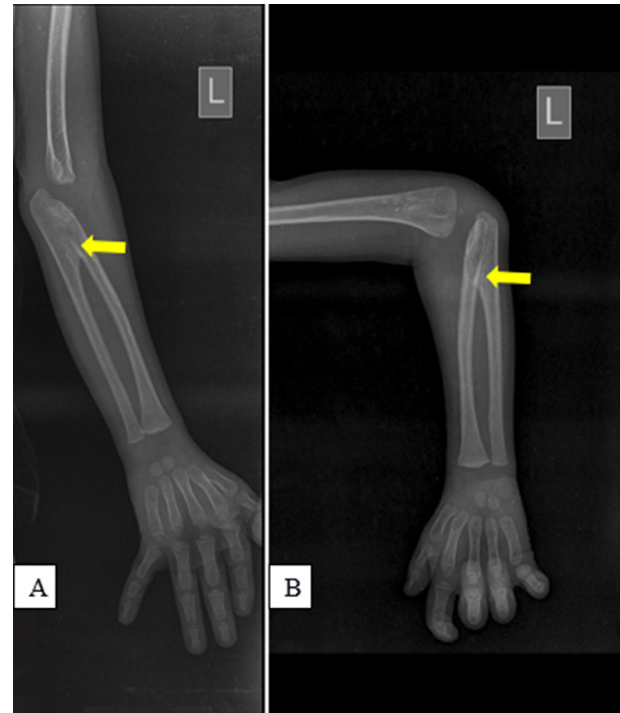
(A) AP and (B) lateral radiographs of the left elbow, radius, ulna, and hand bones showing fused radioulnar bones at the proximal fourth, an absent proximal radioulnar joint and a postero-medial orientation of the olecranon process (yellow arrows).
